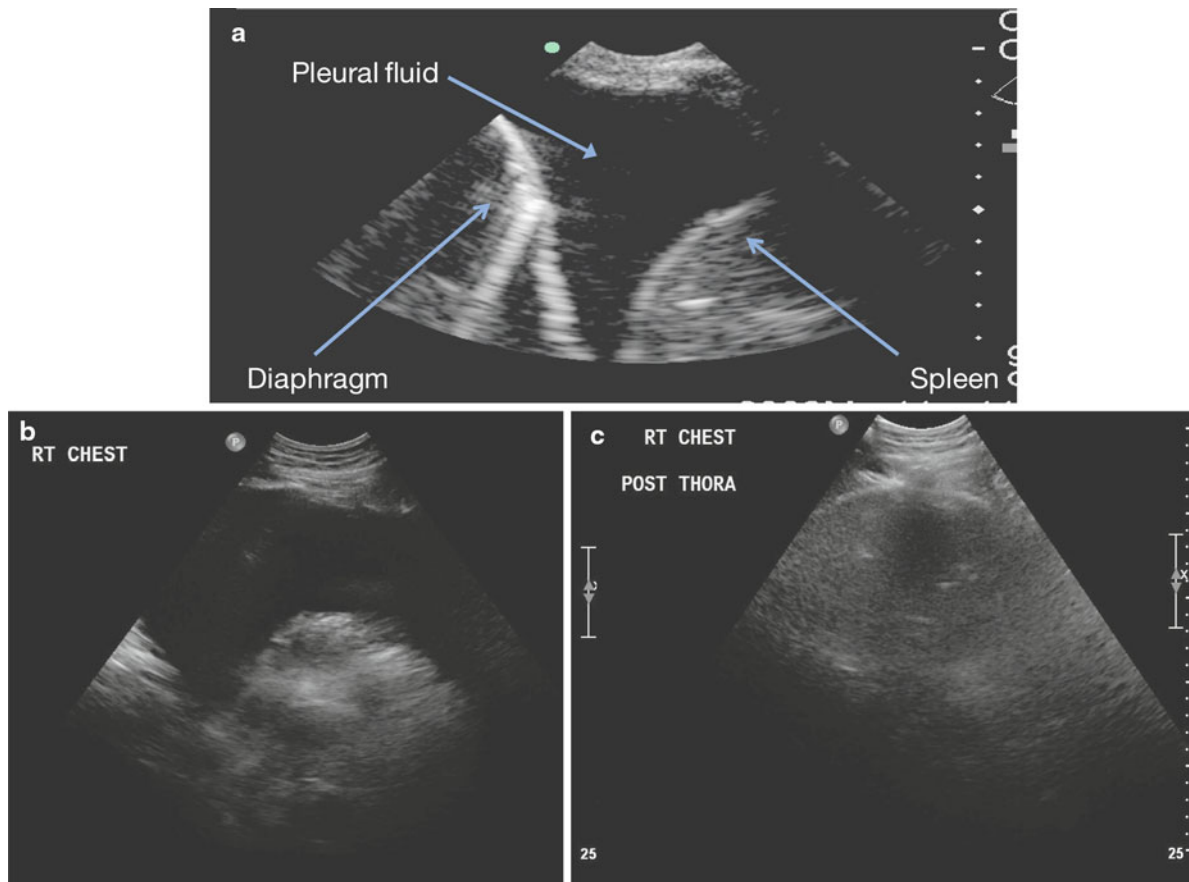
Thoracic ultrasound: (a) Ultrasound demonstrating pleural fluid, diaphragm, and spleen; (b) Demonstration of pleural effusion prior to thoracentesis; (c) Post-thoracentesis
